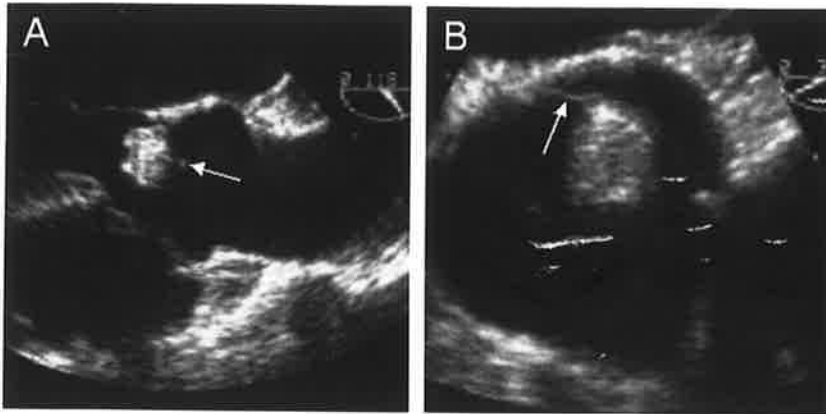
The transesophageal echocardiogram of the (A) long axis view and the (B) short axis view. A hyperechoic homogenous smooth surface mass directly arising from the ventricular side of the left coronary cusp of the aortic valve (arrows).
